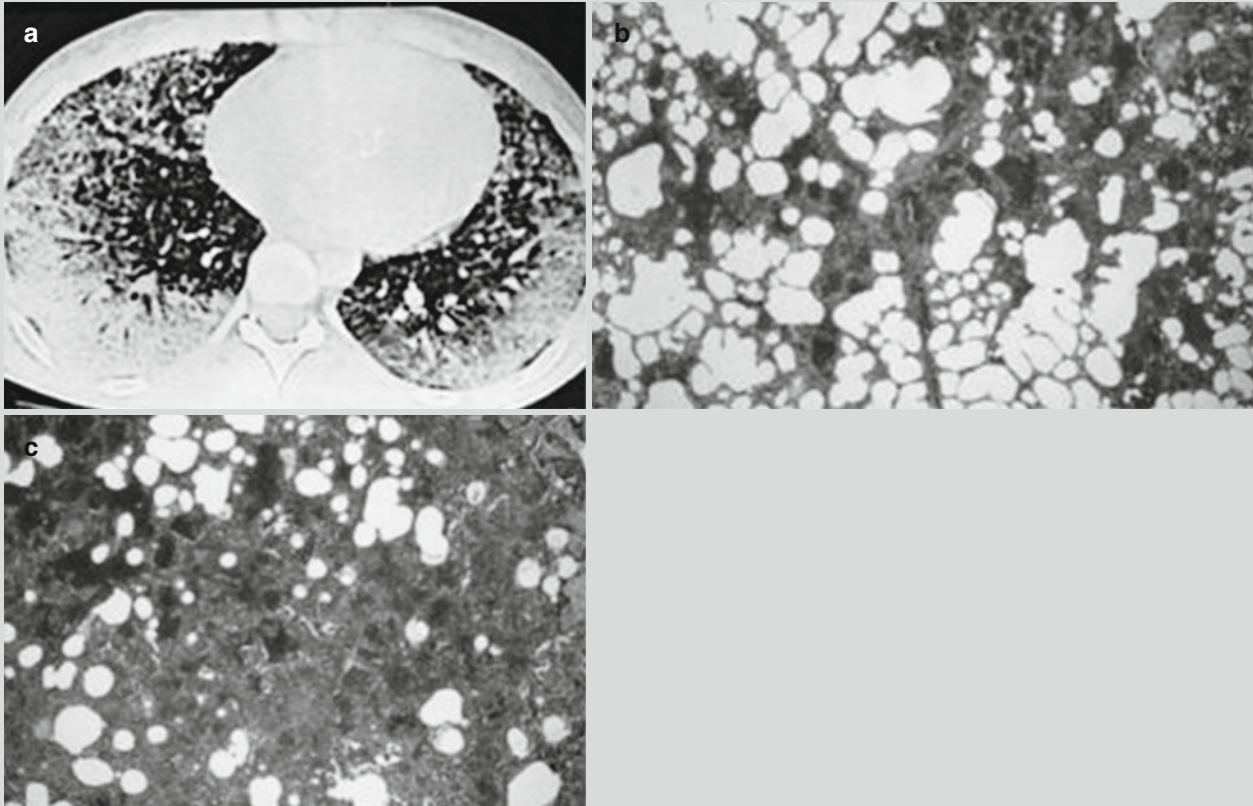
Leptospirosis with pulmonary bleeding. (a) HRCT demonstrates ground-glass and nodular shadows in both lungs and consolidation shadows in the subpleural area. (b) Autopsy under
